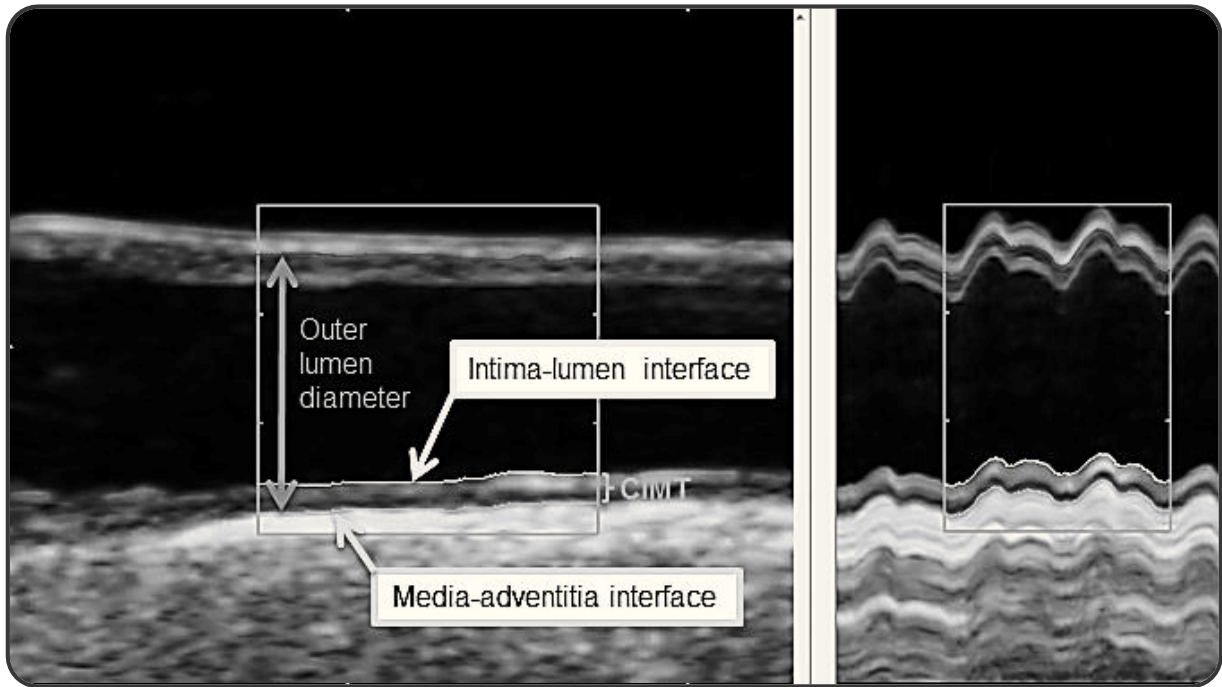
Ultrasound image
